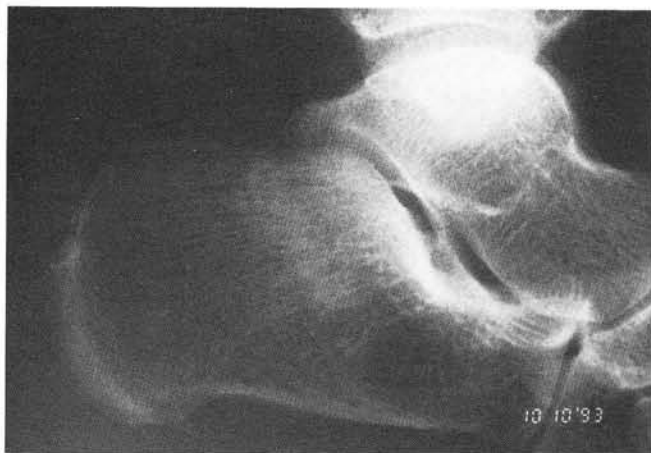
The initial radiograph of insulin diabetic female with heel pain. Note the stress fracture just behind the posterior facet.
